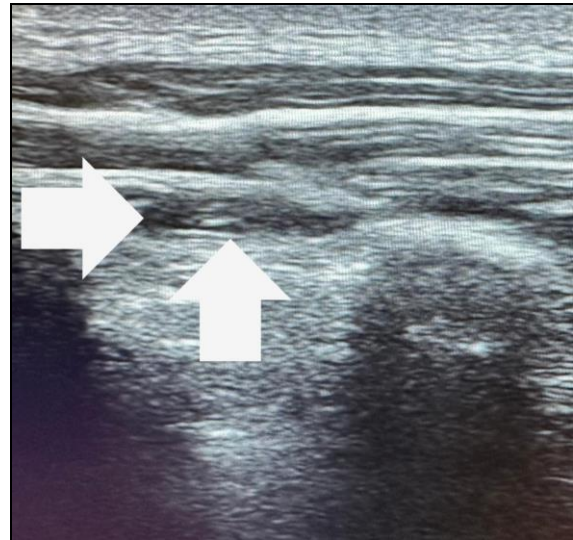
ESP Block Ultrasound Image.
